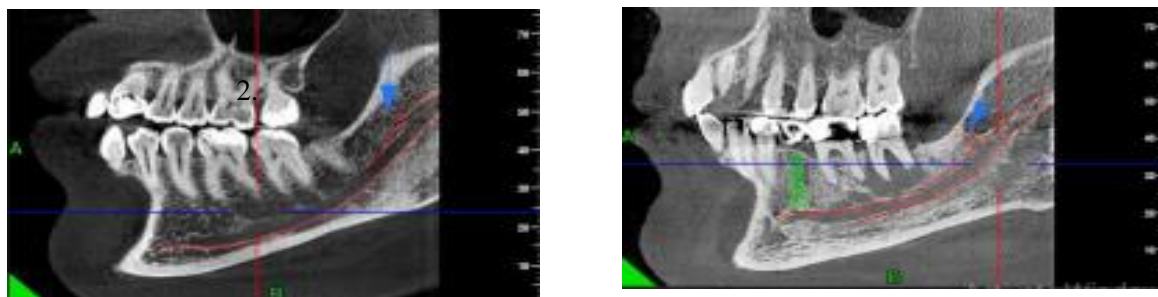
sagittal section of CBCT showing accessory mandibular canal. 1 female, 2 male.
